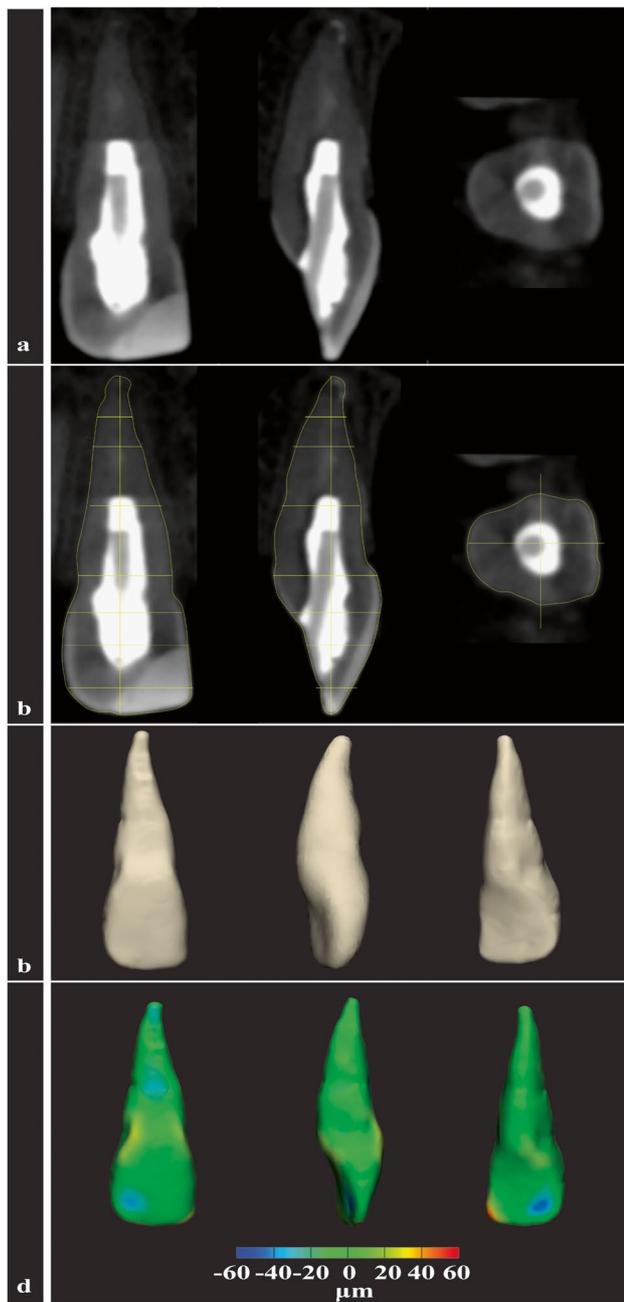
Interest of AI-driven tooth segmentation with: a sagittal, frontal, and horizontal views of the cone-beam computed tomography (CBCT) of a maxillary central incisor presenting artefacts due to the root canal treatment and coronal rehabilitation; b automatic detection of the borders of the tooth (yellow lines) using the AI-algorithm; c automatic 3D segmentation based on the interpolation of the segmented slices (yellow lines); and d vestibular, lateral, and palatal views of a part comparison analysis deriving from the superimposition of expert manual segmentation (taking on average 12 min for completion) and fully automated AI segmentation (<30 s for completion). The colour map depicts a mean deviation of 7.85 μm between the 2 segmentation methods (manual versus AI)
